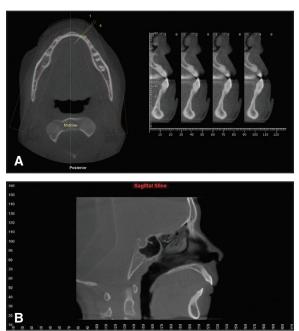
A. Cross-sectional slices of middle-age patient desiring retreatment for relapse (right), showing limited bone availability to resolve Class III crowded dentition. Upper roots are confirmed as short, rather than merely appearing short from excessive flaring (as can occur with panoramic x-ray). Axial view (left) shows narrow trough of bone in which lower incisor roots can be housed (this view requires scrolling through slices to truly evaluate bone availability). Only limited buccolingual tooth movement can take place without periodontal compromise (compare to more typical amount of alveolar bone in axial image of German Template, Fig. 2). B. Sagittal view of different patient's incisors and bone, showing skeletal changes required for overiet resolution. Dental movement alone would force teeth out of existing bone. Lower incisor is already flared, contraindicating additional anterior movement.
